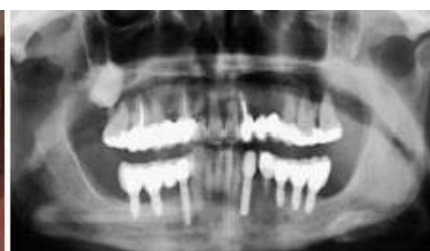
CT scan after prosthetic rehabilitation
